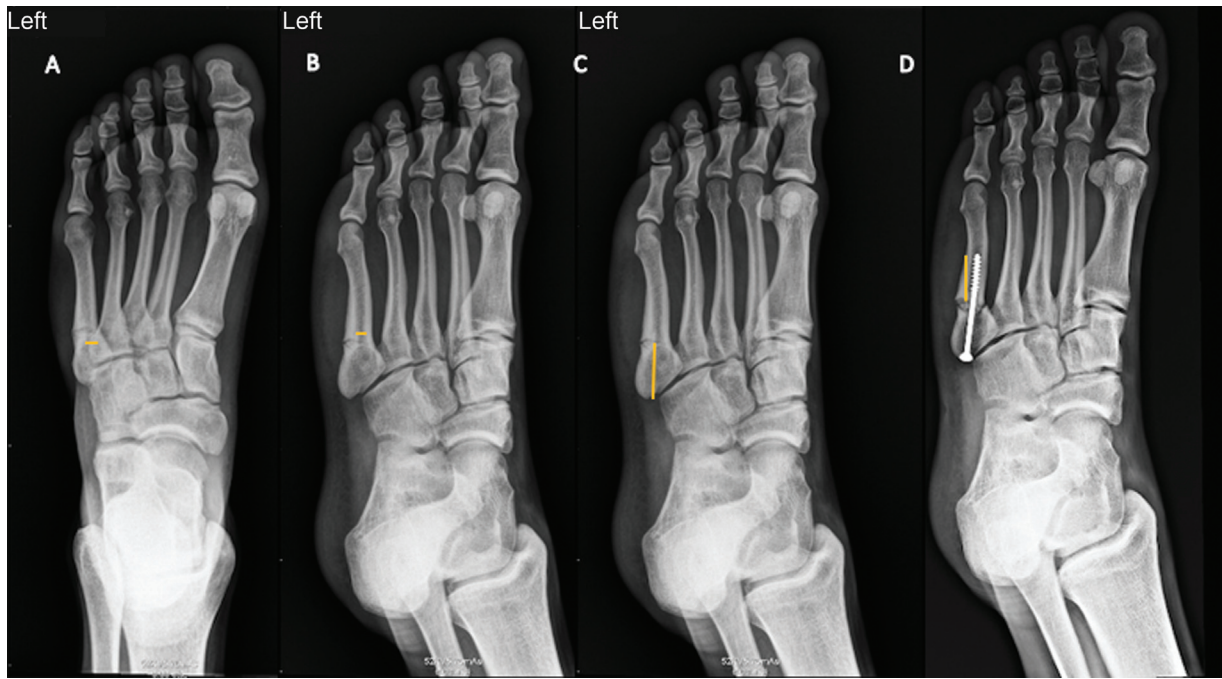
Anteroposterior (AP) and oblique (O) radiographs. (A) Measurement of the diameter of the intramedullary canal on AP projection at the level of the overlap of the fourth and fifth metatarsal bones. (B) Measurement of narrowest point of zones 2 and 3 on O projection. (C) Distance from the proximal edge to the fracture line on O projection. (D) Distance of the screw thread pitch over fracture line on O projection.
